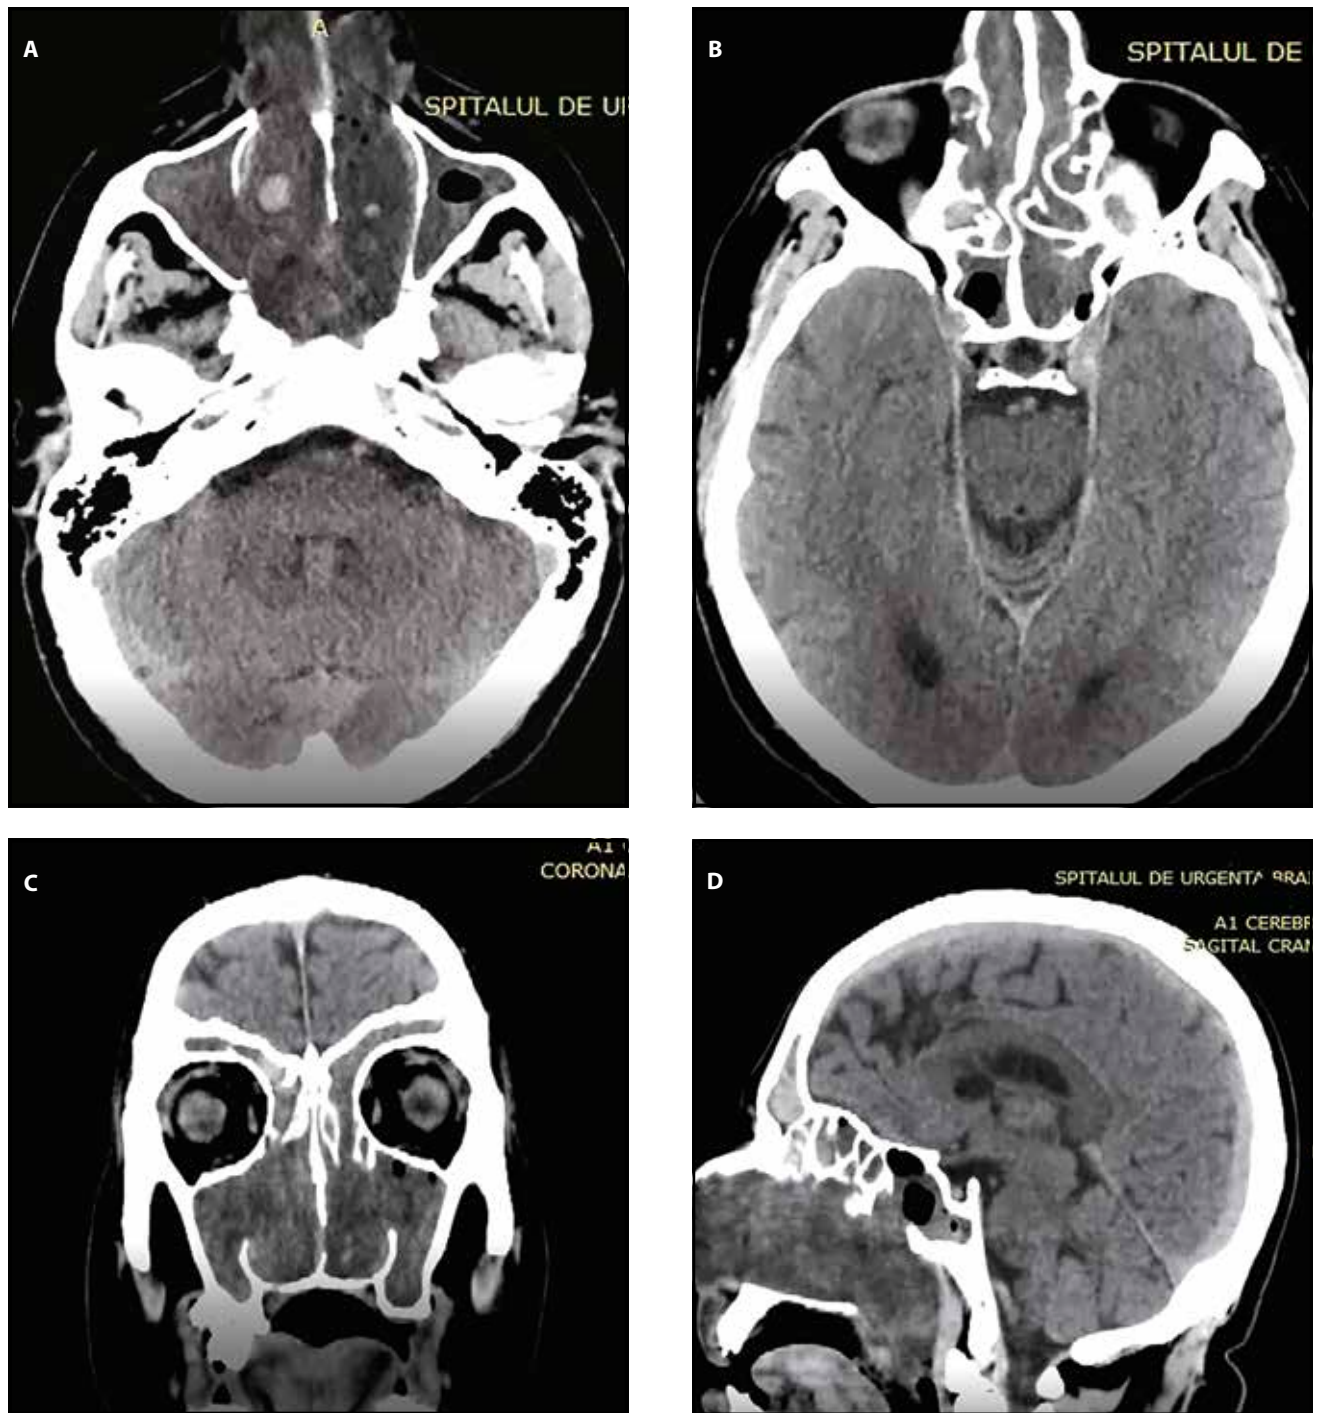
Cranio-facial CT scan: A – axial slice – partially homogeneous tissue mass that completely occupies the paranasal sinuses with partial bone lysis in the medial walls of the maxillary sinuses and partial destruction of the ethmoid intercellular bony septa; B – axial slice – sphenoidal sinuses almost completely occupied by tissue mass; C – coronal slice – complete opacification of the fronto-ethmoido-maxillary sinuses, with partial lysis of the bilateral intersinuso-nasal-maxillary medial wall; D – sagittal slice – tissue mass occupying the frontal sinus, antero-posterior ethmoid, sphenoid and nasal fossa with partial lysis of the ethmoid intercellular bony septa.
